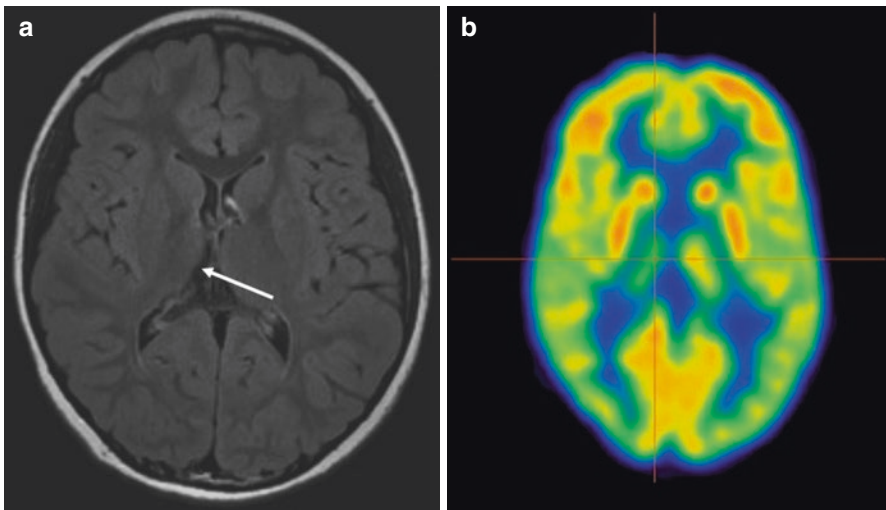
(a) MRI brain: Axial Flair image showing volume loss of the right thalamus (arrow). (b) Axial PET CT image showing corresponding hypometabolism of the right thalamus (cross-hairs)
